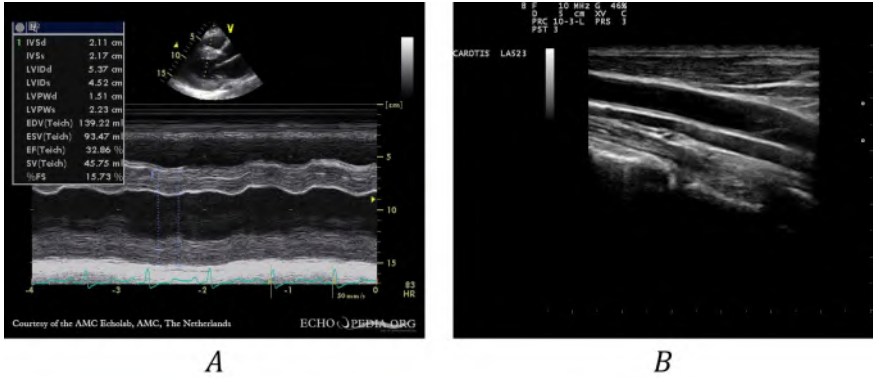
Examples of ultrasound images. A) M-mode scan through a left ventricle of a heart with diastolic dysfunction. B) B-mode scan of a carotid artery. A) Adapted from [https://commons.wikimedia.org/wiki/File:HCM,_diastolic_dysfunction_E00544_\(CardioNetworks_ECHOpedia\).jpg](https://commons.wikimedia.org/wiki/File:HCM,_diastolic_dysfunction_E00544_(CardioNetworks_ECHOpedia).jpg). By CardioNetworks: Secretariat [CC BY-SA 3.0 (<https://creativecommons.org/licenses/by-sa/3.0/>)]; B) Adapted from https://commons.wikimedia.org/wiki/File:CCA_Ultrasound_110318140725_1409520.jpg. By © Nevit Dilmen [CC BY-SA 3.0 (<https://creativecommons.org/licenses/by-sa/3.0/>)].
